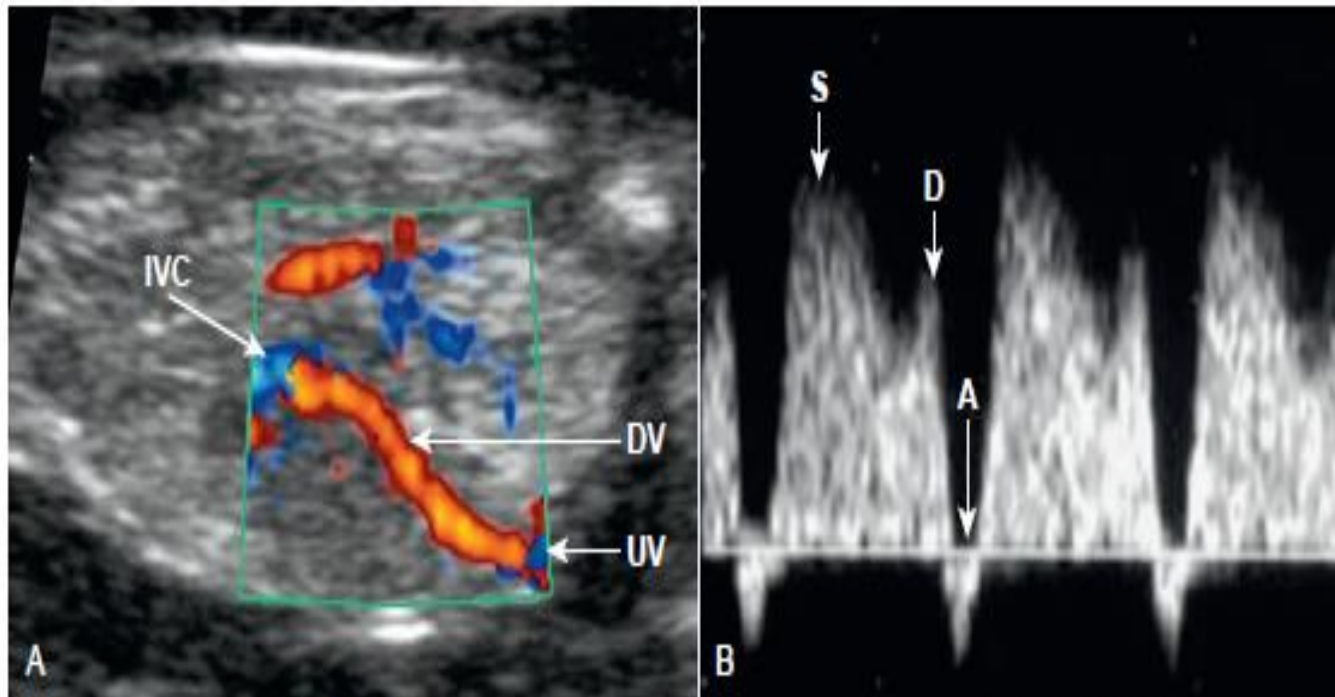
Reversed Flow in Ductus Venosus. (A) Color Doppler anatomy of vessels at oblique sagittal view of fetal trunk. DV, Ductus venosus; IVC, inferior vena cava; UV, umbilical vein. (B) Abnormal ductus venosus sonogram shows a reversed a wave. Absent or reversed a-wave flow can occur in cardiac failure, with or without cardiac defects, and in chromosomally abnormal fetuses. D, Diastole; S, systole.
